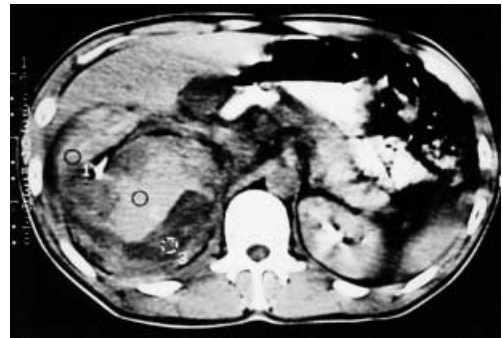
The initial CT scan showed perirenal haematoma and angiomyolipoma was identified as a bleeding source.
